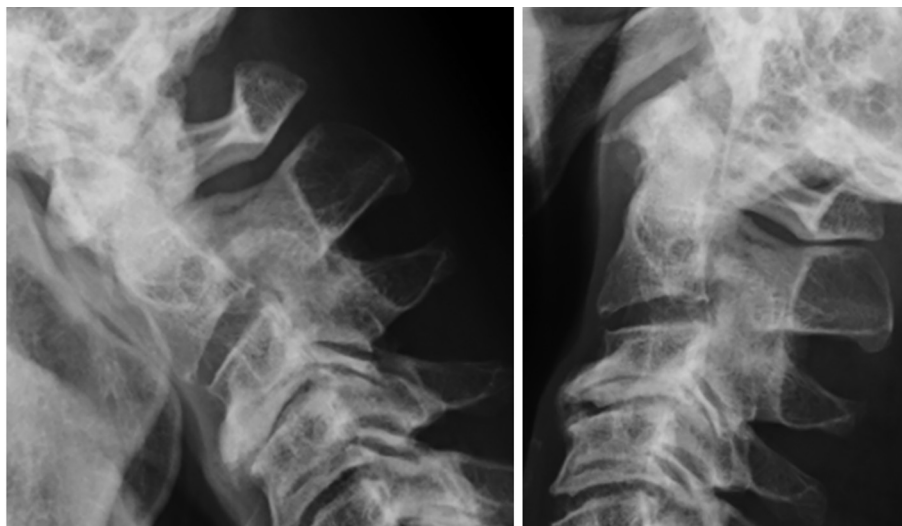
Patient X-ray images. Plain cervical radiographs in flexion (left) and extension (right) showed normal alignment of C1 and C2, with no evidence of atlantoaxial instability (no C1-C2 subluxation on dynamic views).
